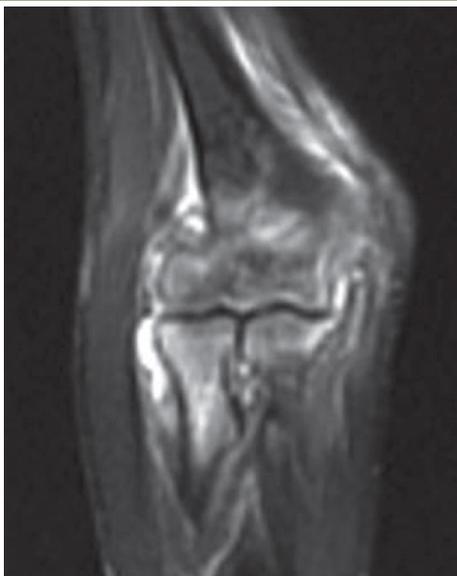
MRI Showing Marked Contrast Enhancement, Changes in Bone Density, Thickening of Synovial Structures, and Contrast Enhancement of the Medullary Bone Marrow and Effusion
